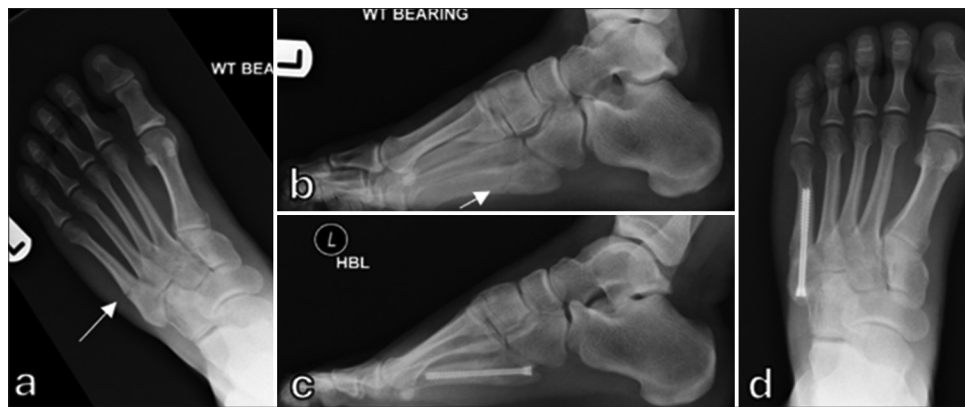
(a) Anteroposterior and (b) lateral radiographs of a 19-year-old professional footballer showing Jones-type fracture (white arrows). (c) Anteroposterior and (d) lateral radiographs 10 weeks later showing union following intramedullary screw fixation.
